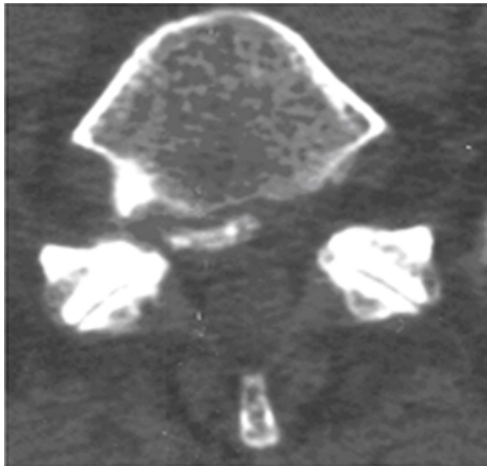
Computerized CT-scan from L2-L3 intervertebral disc. Note the avulsed bony particle from apophyseal rim.
